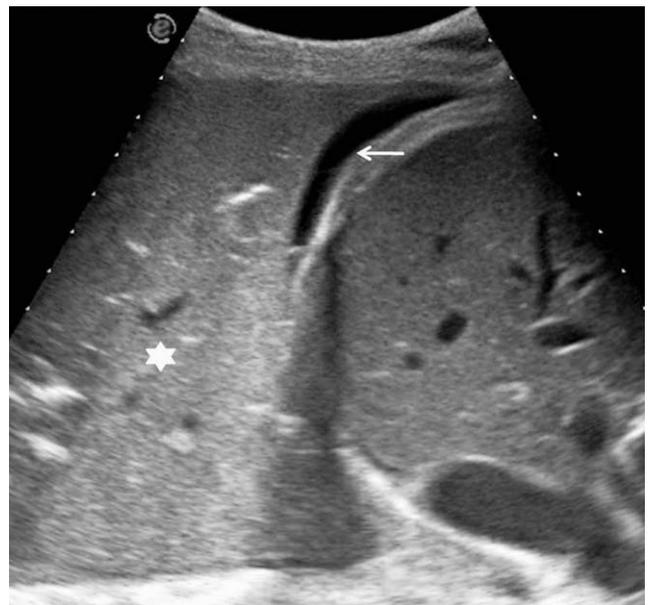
Ultrasound scan of a patient admitted to an intensive care unit with a hard-to-interpret chest radiograph. It shows a large pulmonary consolidation (asterisk) and a very small subpulmonary pleural effusion (arrow).
